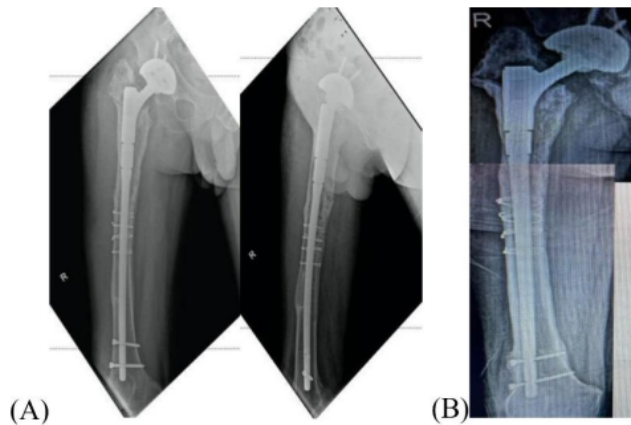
X-ray image after surgery (A) and after 11 months (B)
